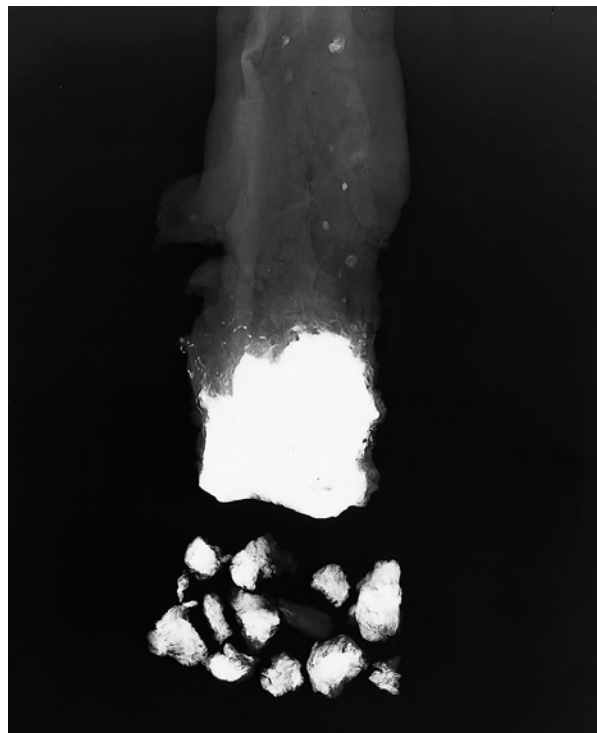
An x-ray of resected rectum and fragments of perirectal tissue demonstrates the presence of the barium 17 months after the barium enema.
